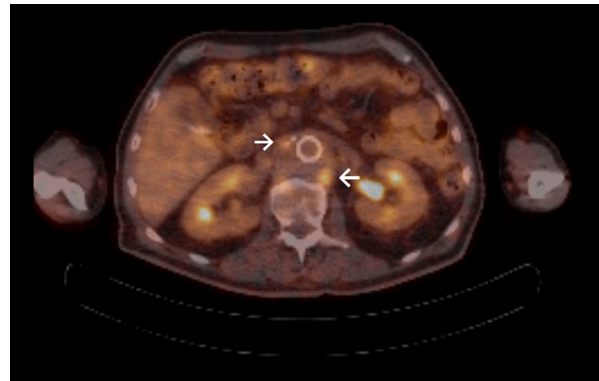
A 2-deoxy-2-[F18]-fluoro-D-glucose-positron-emission tomography/computed tomography (FDG-PET/CT) scan 2 months after surgery shows focal uptake (*arrows*) in the aneurysmal wall, with a standardized uptake value of 4.0.
